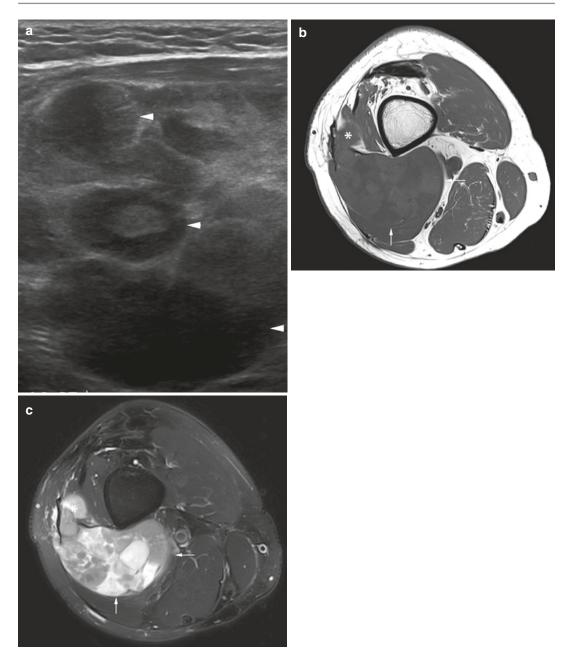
(a–c) Myxoid liposarcoma of the right thigh. (a) Ultrasound. (b) Axial SE T1-weighted MR image. (c) Axial fat-suppressed SE T2-weighted MR image. The mass lies predominantly in the posterior compartment (*arrow*) but is infiltrating into the anterior compartment
